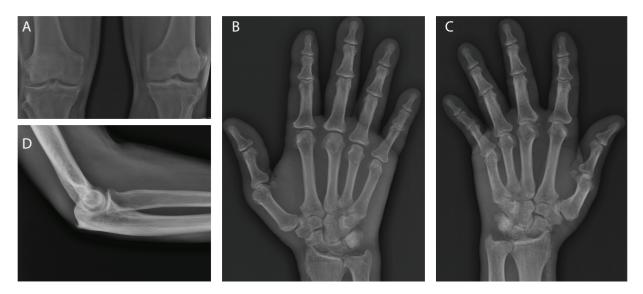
Radiographs showing chondrocalcinosis in meniscus of the knee, fibrocartilage of the wrist and elbow.
